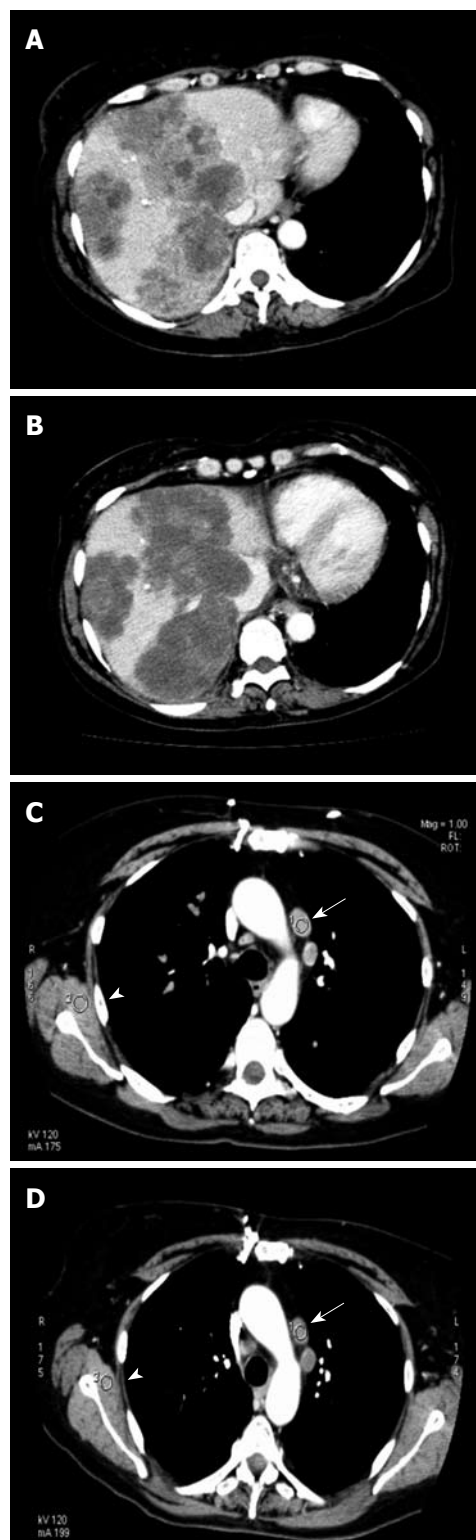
Representative CT scan of patients responding according to Choi criteria. A: (Patient 5) Contrast-enhanced CT-scan (arterial phase) showed three large liver metastases before inclusion; B: Two months later, a significant decrease in the enhancement of the metastases was observed by CT performed under the same conditions (arterial phase). Although lesions were classified as stable disease using RECIST criteria, they could be considered as a partial response using Choi criteria; C: (Patient 8) Contrast-enhanced CT-scan (arterial phase) showed two latero aortic lymph node metastases. Density was 82.8 UH (arrow). To assure comparability, density was also measured in muscle (72.8 UH) (arrow head); D: After 2 mo, although size of lymph node metastases was stable, there was a significant decrease in density (59 UH) (arrow), which led to a partial response using Choi criteria. In comparison, muscle exhibited no decrease in density (73 UH) (arrow head).
